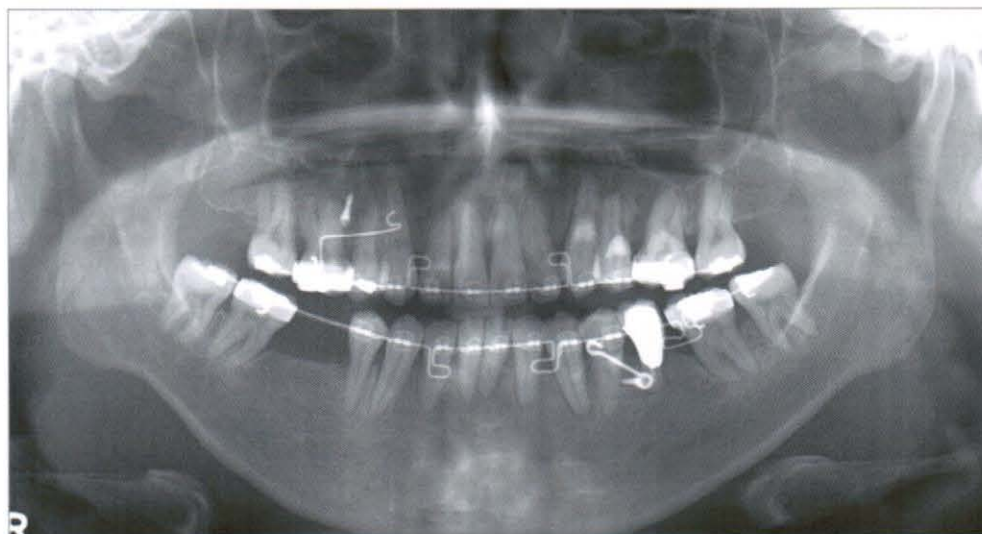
Recent panoramic radiograph (2008, 2,12)
